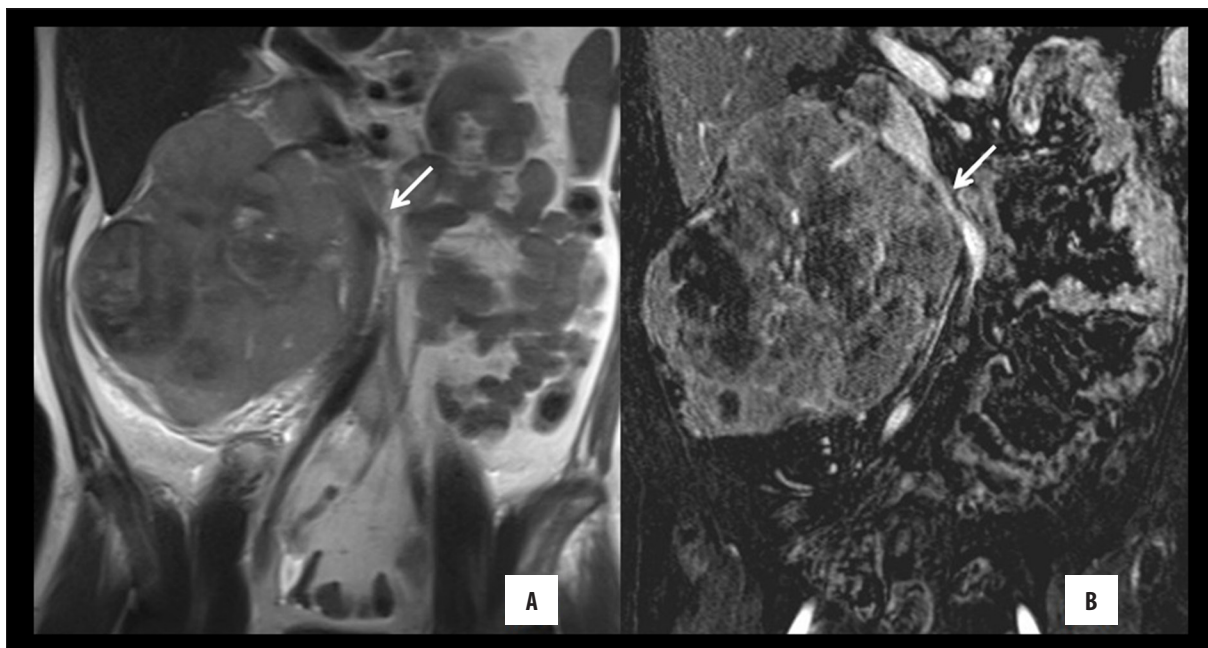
Coronal T2-weighted HASTE (A) and T1-weighted post-contrast subtraction images (B) showing the vascular displacement of the inferior vena cava (arrow).
